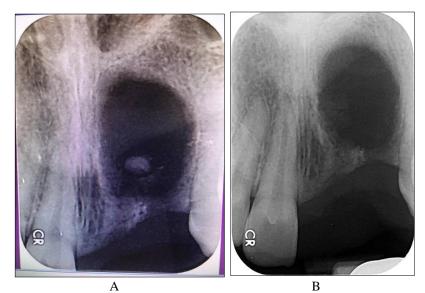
(A): Showing; a well-defined radiolucency a well-defined radiolucency at the area of extracted tooth, (B): Periapical radiograph one week after the surgery
